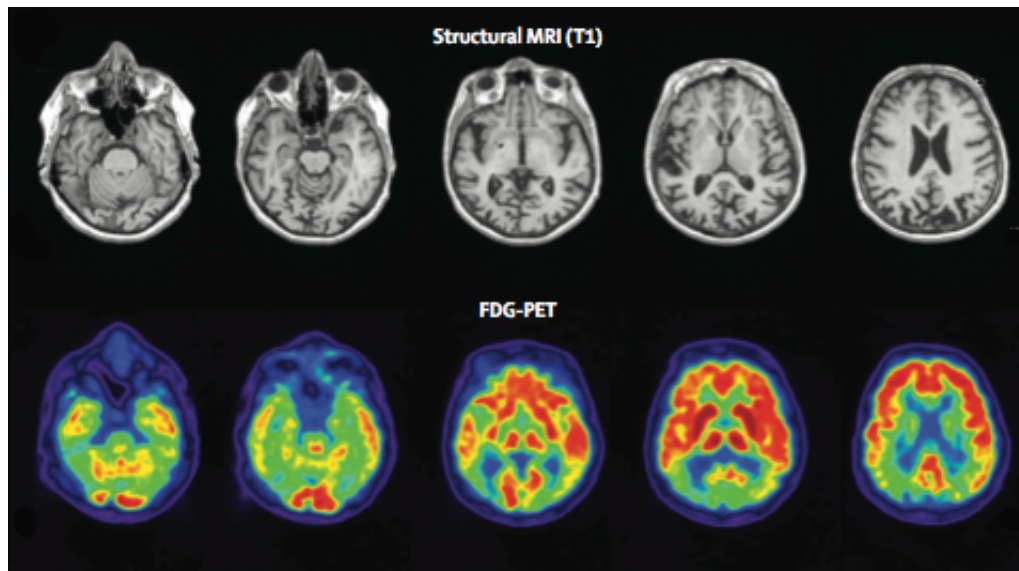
Structural and FDG-PET scan from a PCA patient. Note the presentation of posterior cortical atrophy in the structural scan, and reduced posterior metabolism in the FDG-PET scan. Adapted from [20].
